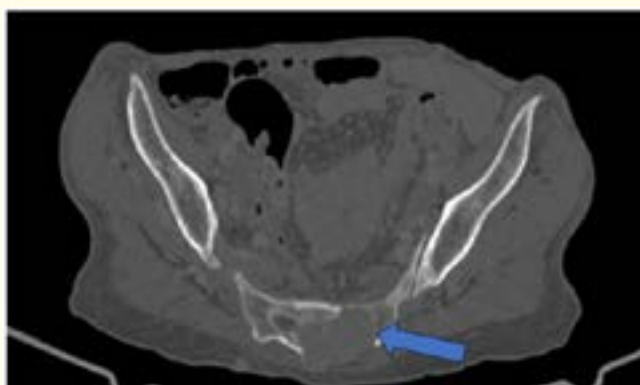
Axial portal venous-phase pelvic CT scan (bone window) demonstrating a tissue-density lytic lesion of the sacrum (blue arrow), with cortical destruction and extension into the sacral canal, resulting in invasion of the canal contents including the sacral nerve roots.
